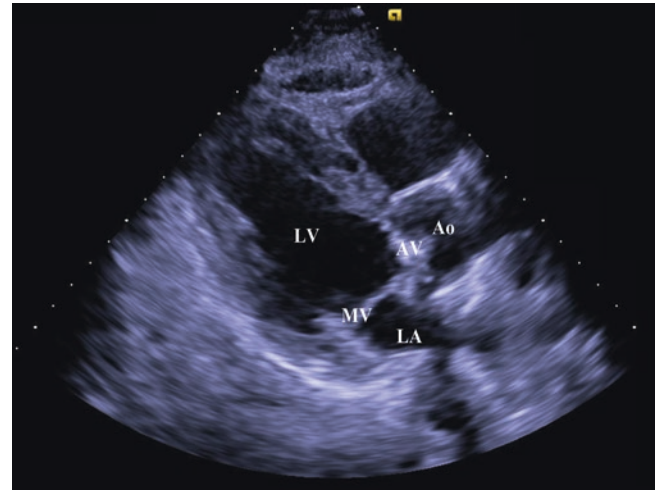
Aortic stenosis in the parasternal long-axis view. An attempt to visualize the aortic valve opening should be made in the parasternal views. In this parasternal long axis view the left ventricle (LV), left atrium (LA), mitral and aortic valves, and the aortic root (Ao) are seen. The mitral valve (MV) appears echo bright but opens normally. The aortic valve (AV) appears echo bright with very restricted leaflet opening suggestive of aortic stenosis. See also Video 20.6
